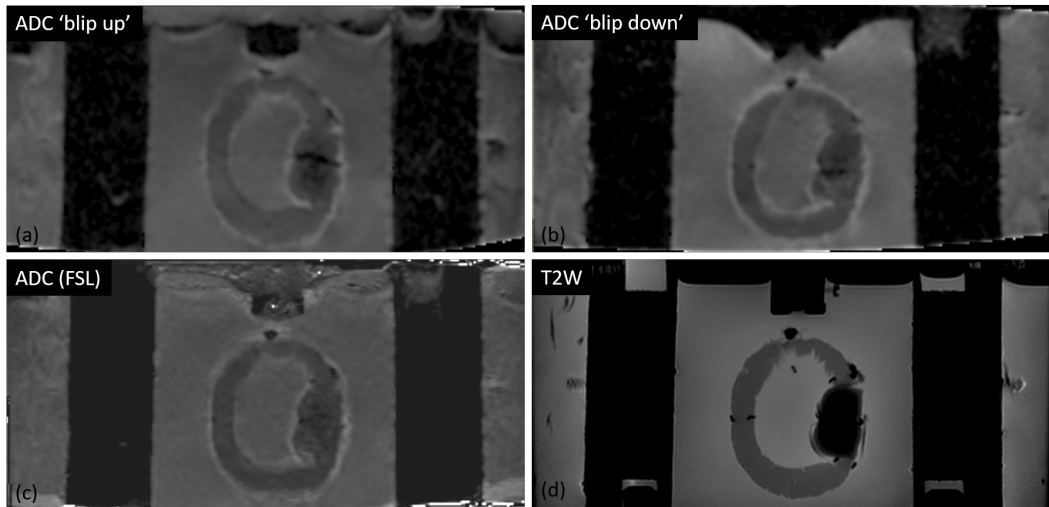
ADC maps where (a) ‘blip up’ and (b) ‘blip down’ refer to k-space readout direction showing distortion primarily in the relevant readout direction; (c) the ADC (FSL) map was recalculated following distortion-correction of acquired DW-MRIs using FSL and (d) T2W-MRI for comparison.
